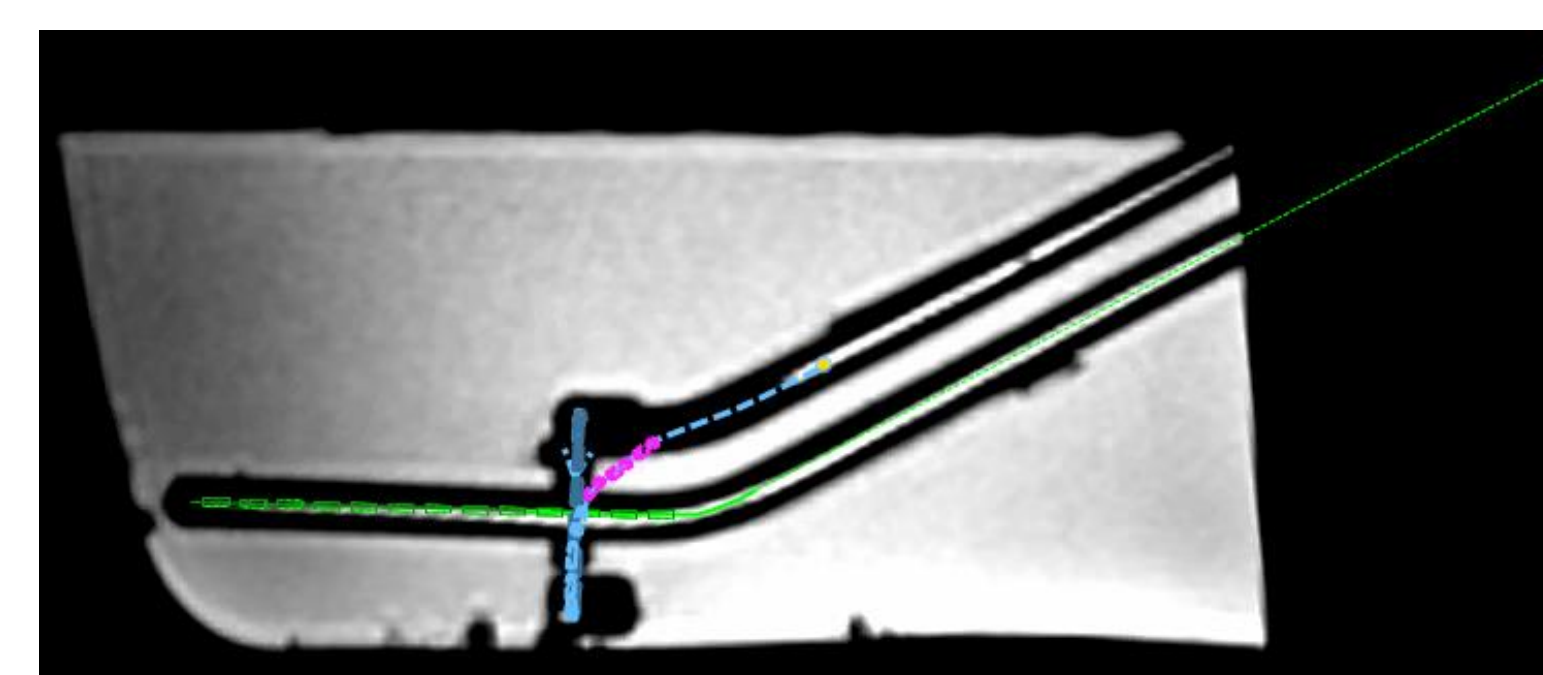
Localization of the HDR applicator channel using the MRI-positive contrast marker on a T1-weighted image.
